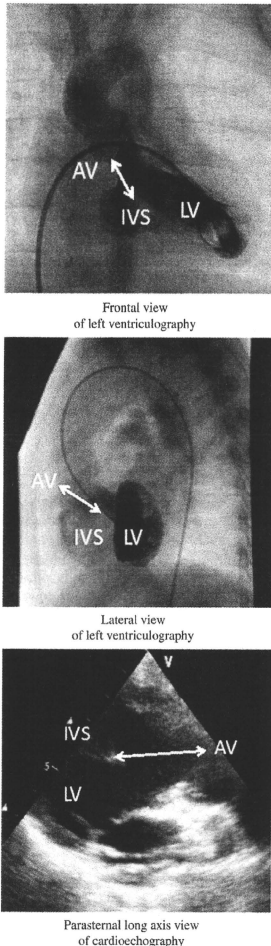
The measurement of the length between the top of the interventricular septum and the aortic valve (IVS–AV length). The length between the top of the interventricular septum and the aortic valve (IVS–AV length) was measured by the parasternal long axis view of echocardiography and by either a frontal view or a lateral view of a catheter examination. AV, aortic valve; IVS, interventricular septum; LV, left ventricle.
